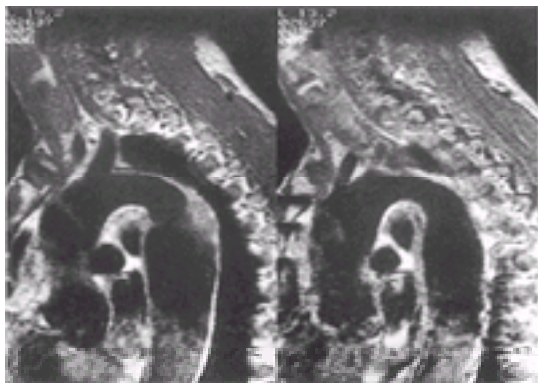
MRI scan in longitudinal plane after type A aortic dissection.
